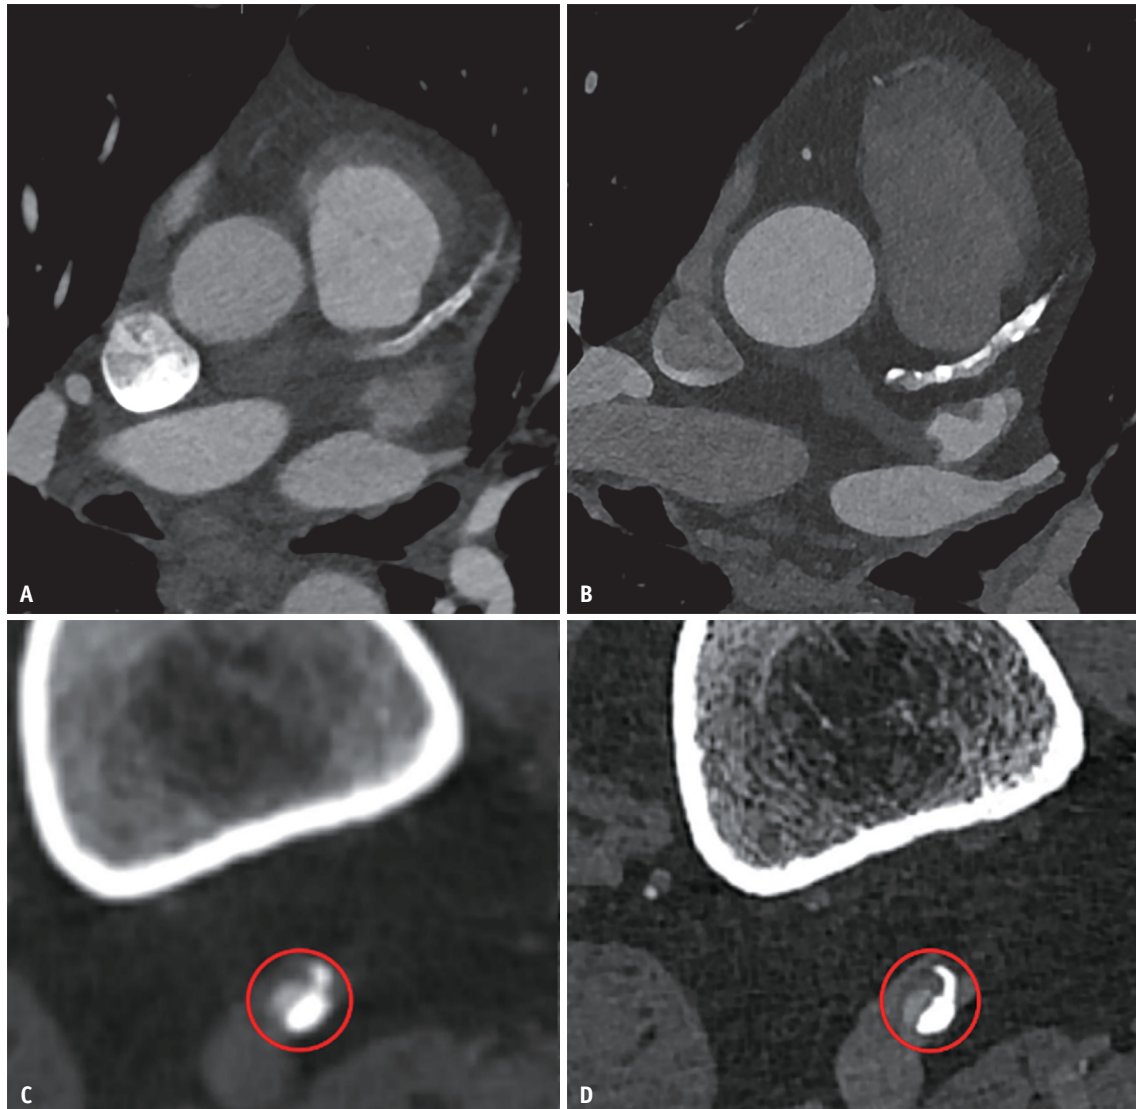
Improved assessment of dense calcified arteries. A: Axial oblique coronary CTA from an EID-CT scanner in a 71-year-old male shows dense calcified plaque in the proximal and mid left anterior descending coronary artery, resulting in severe stenosis. Calcium margins are poorly defined. B: Coronary CTA in the same patient from a PCCT scanner shows sharper plaque definition with reduced blooming, revealing moderate stenosis. By reducing blooming, PCCT enables more accurate estimation of luminal stenosis, which correlates more closely with invasive coronary angiography. C: Axial CTA in a 75-year-old male shows a heavily calcified popliteal artery with severe stenosis and marked calcium blooming on EID-CT (red circle). D: Axial CTA in the same patient from PCCT shows sharper plaque definition, reduced blooming, and improved assessment of stenosis (red circle). CTA = CT angiography, EID = energy-integrating detector, PCCT = photon-counting CT
